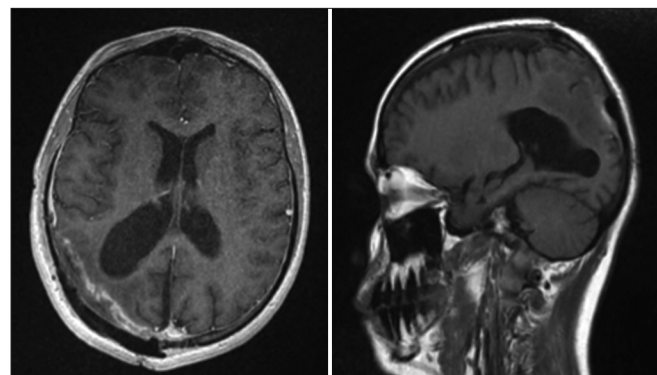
Postoperative brain magnetic resonance imaging showing complete total resection.
